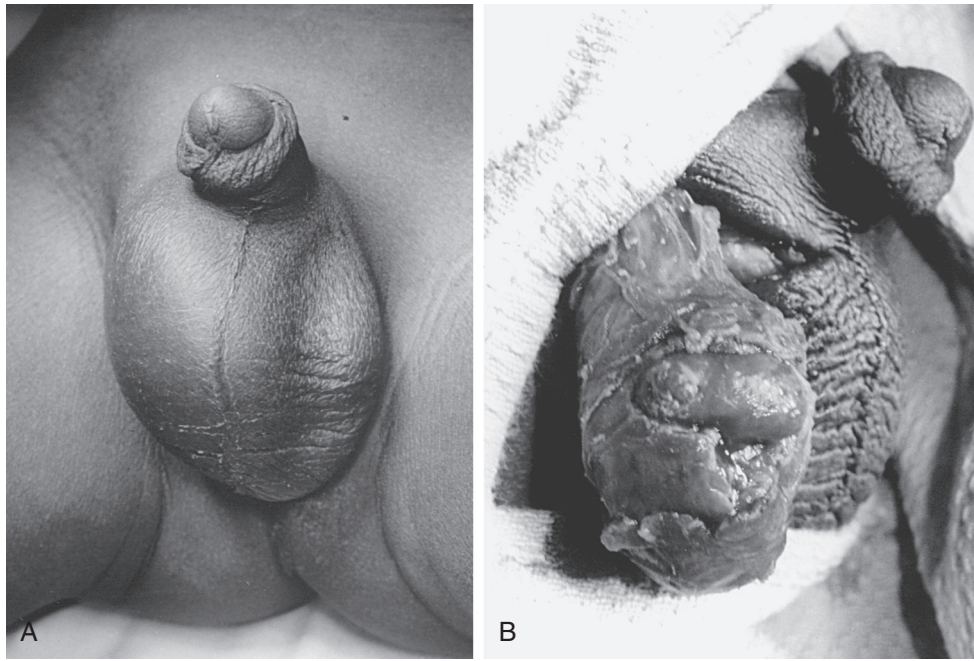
A, Appearance in an 8-year-old male kicked in the scrotum while performing karate with his brother. Note right scrotal swelling. An ultrasound study showed scrotal hematoma and a ruptured testis. B, Scrotal exploration shows a nonviable testis. Orchiectomy was performed.
